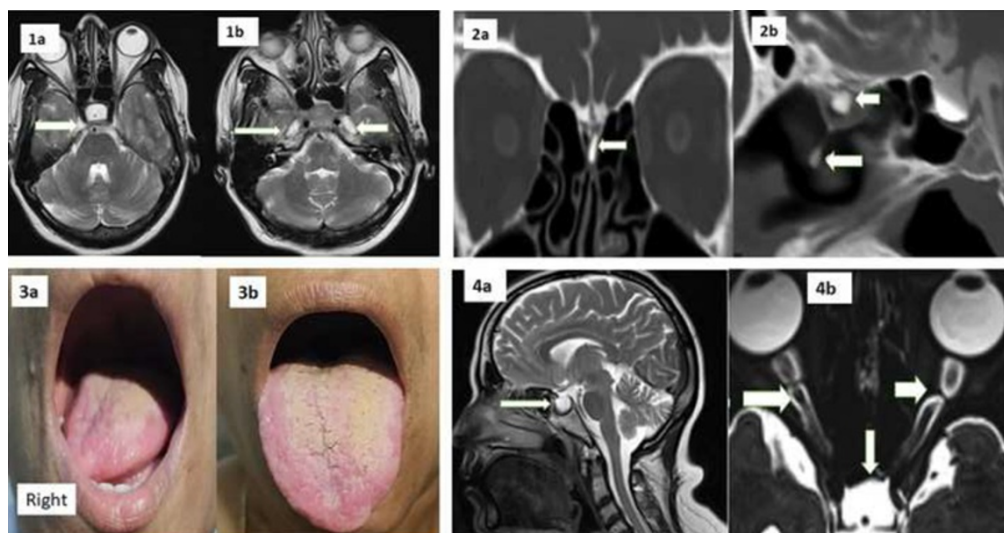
Magnetic Resonance Imaging (MRI) brain T2 axial section (1a,1b) showing bilateral Meckel's cave enlargement, Computed Tomography cisternography brain with contrast coronal (2a) and sagittal (2b) sections showing bony defects in the posterior cribriform plate with cerebrospinal fluid (CSF) leakage. Image showing deviation of tongue to right side in resting position (3a) and deviation to left side on protrusion of tongue (3b) s/o left 12th nerve palsy. MRI Image sagittal section showing complete empty sella (4a) and axial sections showing enlargement of perioptic sheath CSF space with tortuosity of optic nerve and flattening of posterior orbital globe in case of possible IIH without papilledema.
